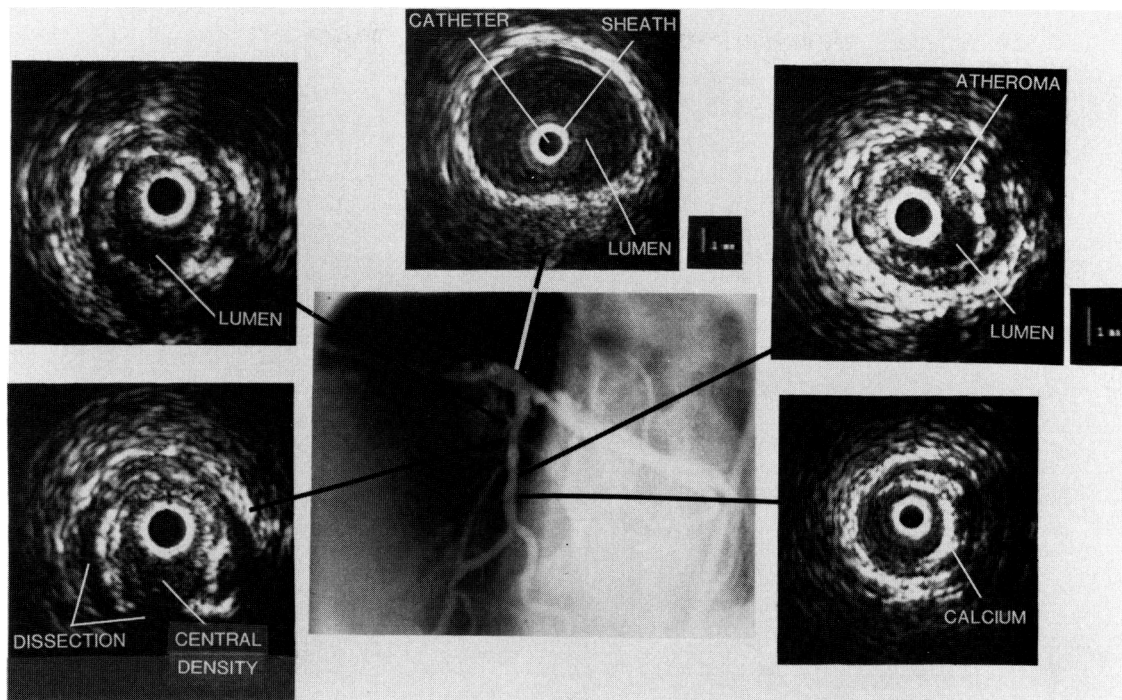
(Continued). Panel D: *Ultrasound images obtained from the various levels of the left coronary artery. Moving in the proximal to distal direction down the artery, 1) left main coronary artery shows a large cross-sectional area with mild atheroma involvement (22% of the cross-sectional area); 2) proximal to the dilated stenotic segment, significant atheroma occupied 61% of the cross-sectional area; and 3) ultrasound image corresponds to the level of the balloon dilatation. Lumen is compromised with a large atheroma mass occupying 78% of the cross-sectional area. Calcification occurs within this atheroma with echo dropout peripherally, which was not observed on fluoroscopy. Patchy echo-reflective structure in the central-inferior region could represent residual atheroma or thrombus. This central echo-reflective structure was not observed in the lumen of the artery, a few millimeters in proximal or distal directions. 4) Distal to the original stenosis, angiogram demonstrates a segment with a 20% diameter stenosis. By ultrasound, atheroma involvement is 64% of the cross-sectional area of the artery at this level. 5) Ultrasound image was taken at a more distal level that appeared normal by angiography. Ultrasound image reveals a relatively large lumen, 3.4×3.3 mm in diameter and 8.9 mm^2 in cross section. However, an eccentric atheroma occupies 9.3 mm^2 or 51% of the total cross-sectional area and had intense echoes consistent with calcification.*
